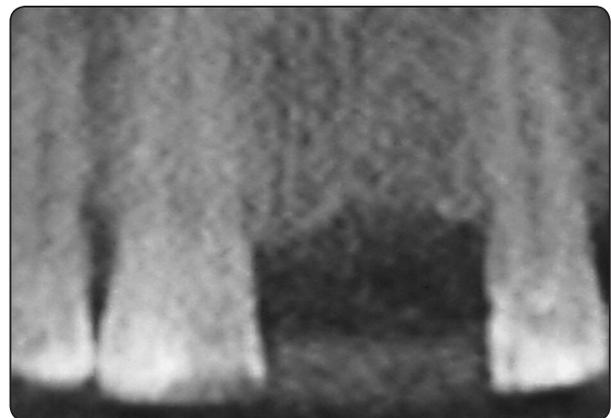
Preoperative periapical x-ray
